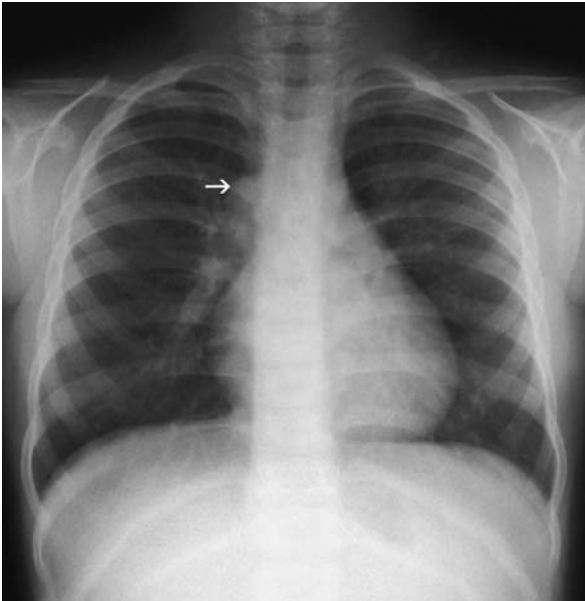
In this 4-year-old asymptomatic girl, a bulge was noted at the junction of the right main-stem bronchus and trachea (*arrow*). It did not pulsate, nor did it affect the esophagus. It was not seen on the lateral film. At ultrasonic examination, the intrahepatic vena cava was found to be atretic, leaving just an infrarenal vena cava. The mass is the azygos vein, which returns blood from the abdomen to the heart. This condition is called azygous continuation of the inferior vena cava
